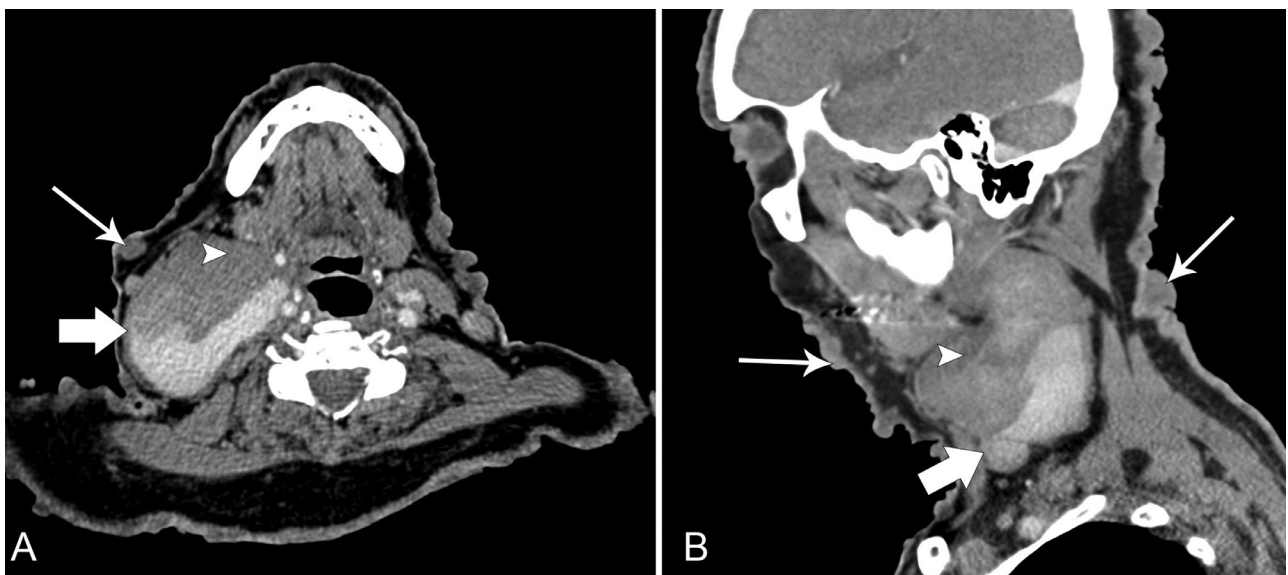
Contrast enhanced CT neck, (A) axial view showing a large right neck lesion originating from the right internal jugular vein (arrow) showing contrast layering in the dependent part and partial thrombosis anteriorly (arrowhead). (B) Parasagittal view showing the location of the large aneurysm and the numerous skin lesions (long arrow).
